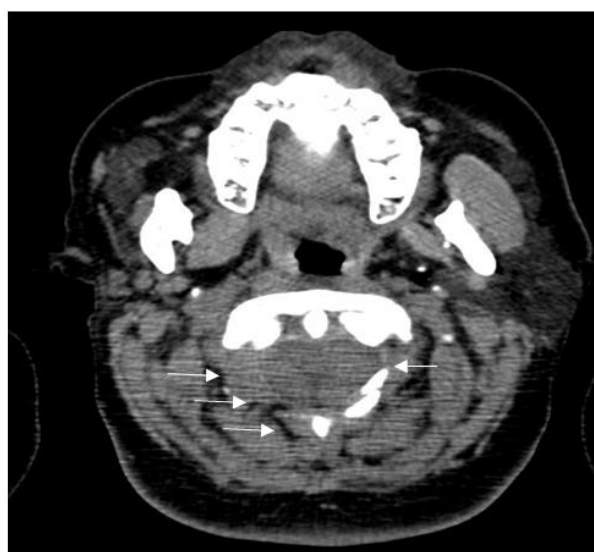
Cervical spine CT scan: axial section, C1 posterior arch closure defect (arrows)
